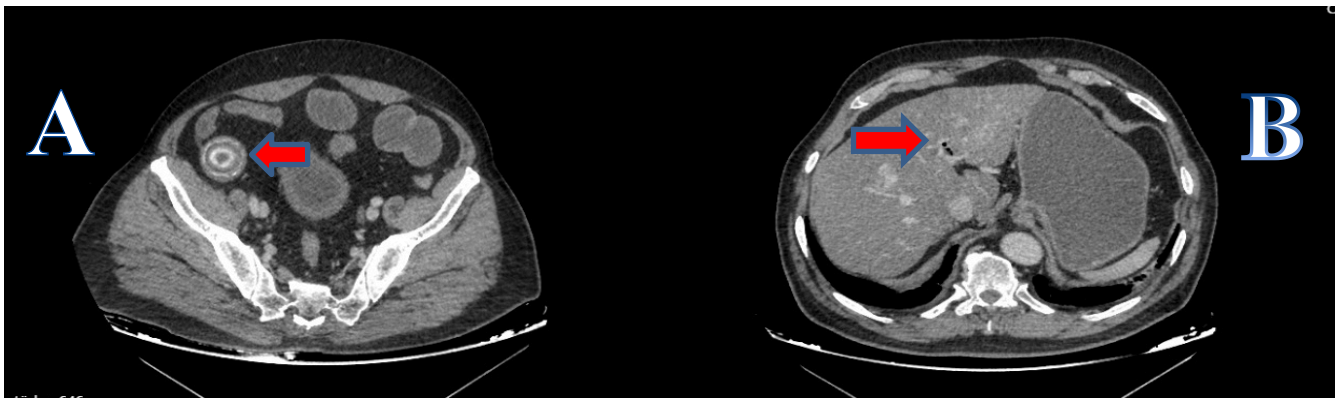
A. Computed tomography image of stones, which caused ileus B. Pneumobilia image on computed tomography (shown with red arrows)
